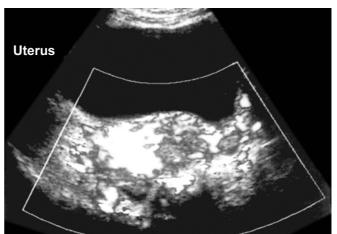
Uterine and adnexal (pelvic) arteriovenous malformation: the extensive colour signal is seen on axial power Doppler imaging (*Courtesy:* Dr Manpreet S Gulati)
